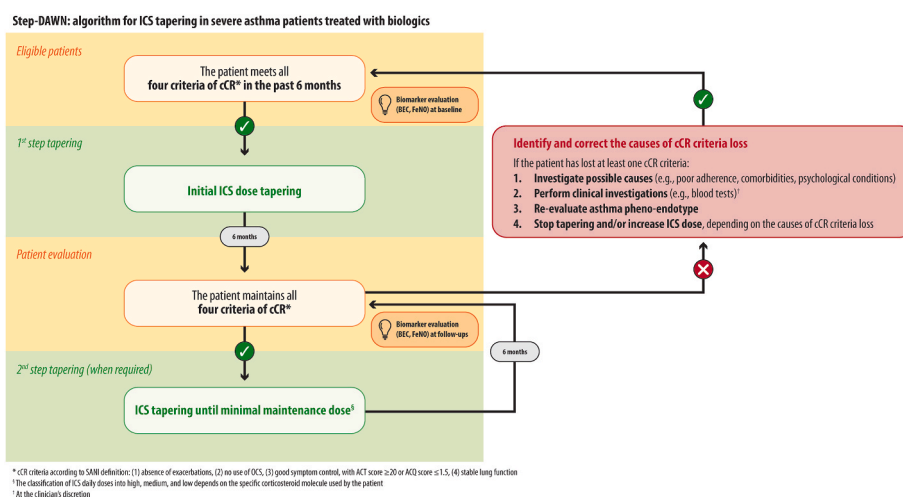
The Step-DAWN protocol. ACT: asthma control test; ACQ: asthma control questionnaire; cCR: complete clinical remission; CT: computed tomography; FeNO: fractional exhaled nitric oxide; GINA: global initiative for asthma; ICS: inhaled corticosteroids; IgE: immunoglobulin E; OCS: oral corticosteroids; SABA: short-acting β_2 -agonist; SANI: severe asthma network in Italy; SMART: single maintenance and reliever therapy.
